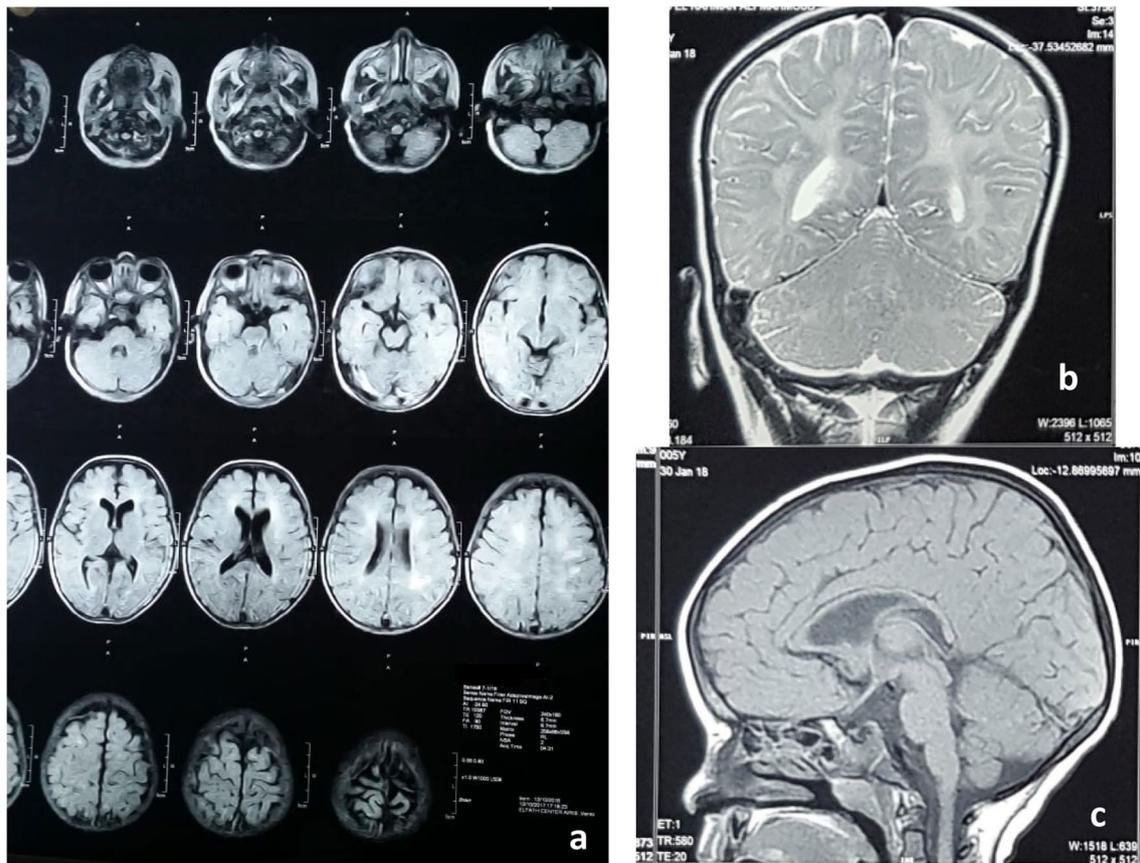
Brain MRI showing; a white matter demyelination in patient 2, and b and c coronal and sagittal sections showing increased signal of white matter and hypogenesis of corpus callosum in patient 9
